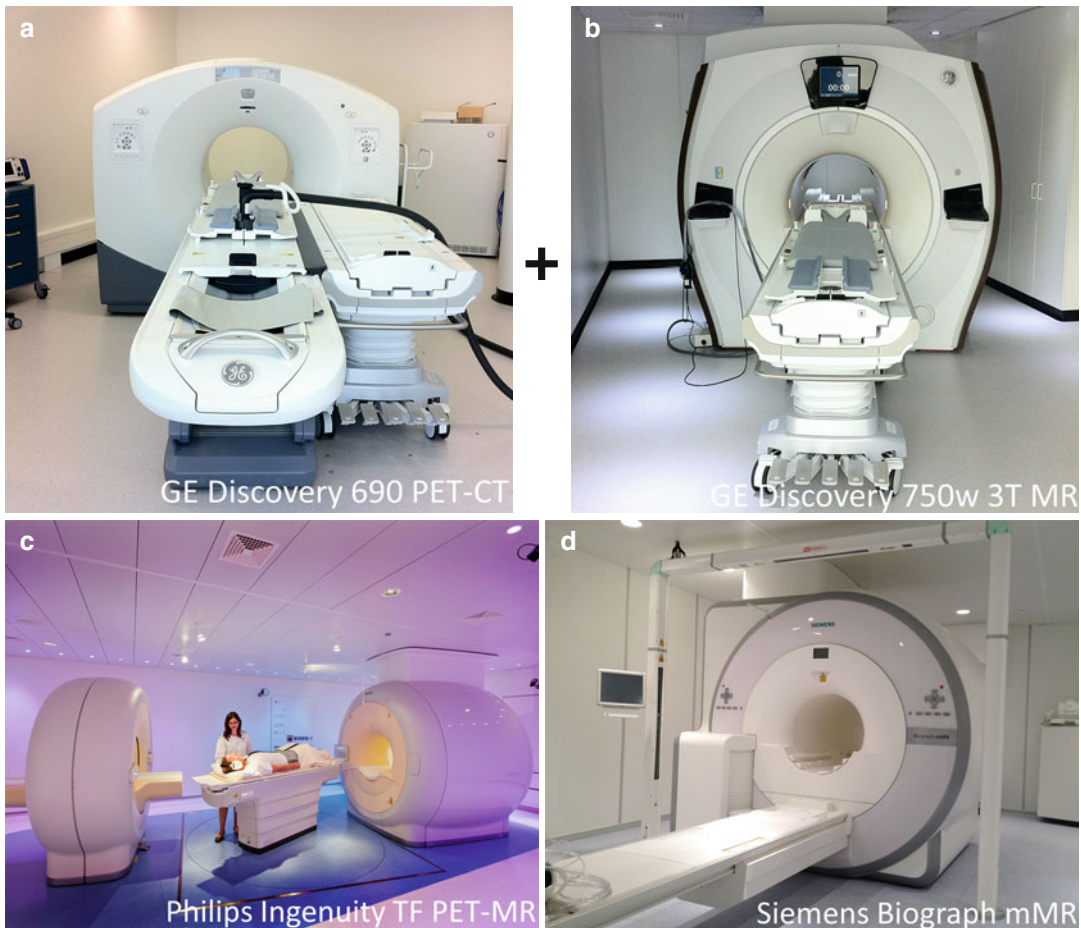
The three commercially available combined PET and MR imaging devices as of today (summer 2013). (a) GE Discovery 690 PET-CT with air hovered board mounted onto a mobile shuttle system combined with (b)
